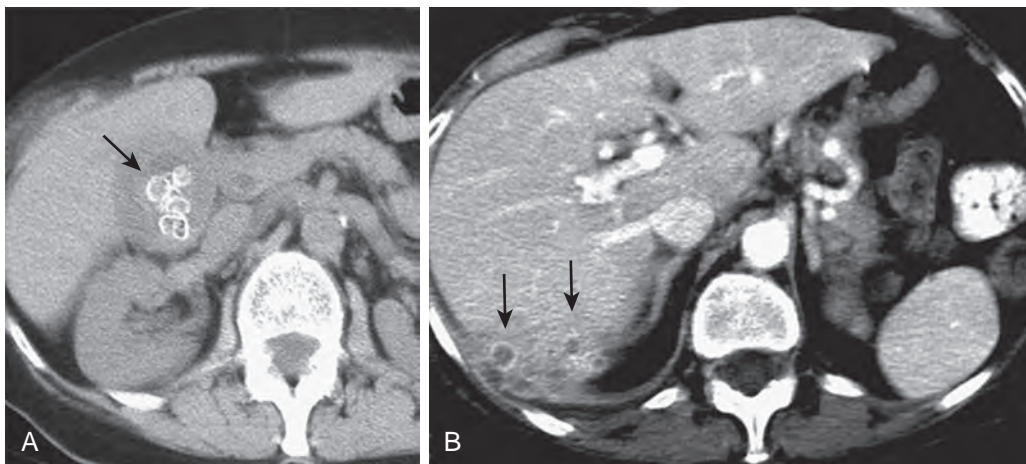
Spilled gallstones after laparoscopic cholecystectomy. A. Contrast-enhanced CT obtained before surgery demonstrates multiple calcified stones in thick-walled gallbladder (arrow) with pericholecystic fluid, indicating acute cholecystitis. B. CT obtained 1 year after cholecystectomy when the patient returned with right upper quadrant pain demonstrates abscess posterior to the right hepatic lobe containing spilled stones (arrows).
